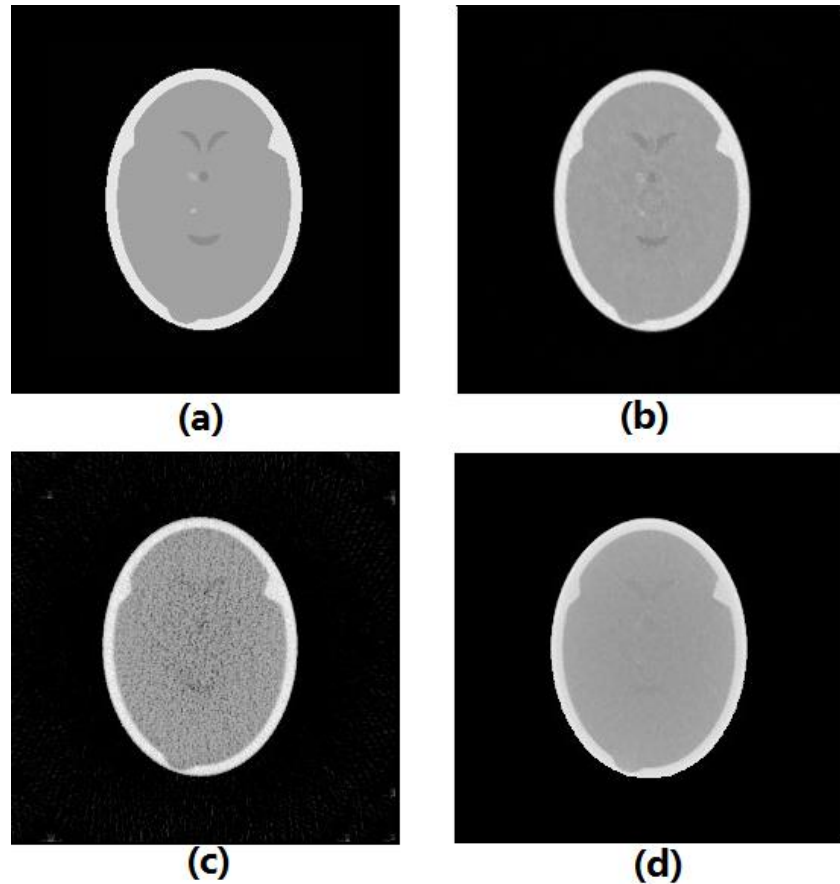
(a) Reference SPR image. Reconstructed SPR images using (b) the DECBCT approach, (c) the 120 kV CBCT image reconstructed with FDK-FBP, and (d) using the 120 kV CBCT image reconstructed with TVS-DROP.
